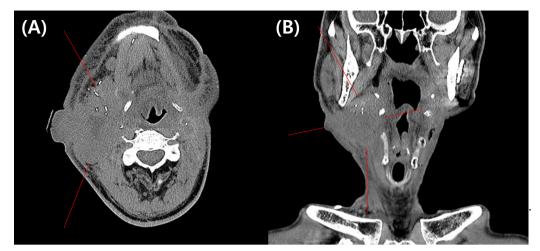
Enhanced CT view of Case 2 patient obtained on admission with the complaint of dyspnea and orthopnea demonstrates a severely narrowed airway space. Recurrent squamous cell carcinoma (red indicators) in right submandibular and cervical area. (A) Axial view, (B) Coronal view. CT, computed tomography.
